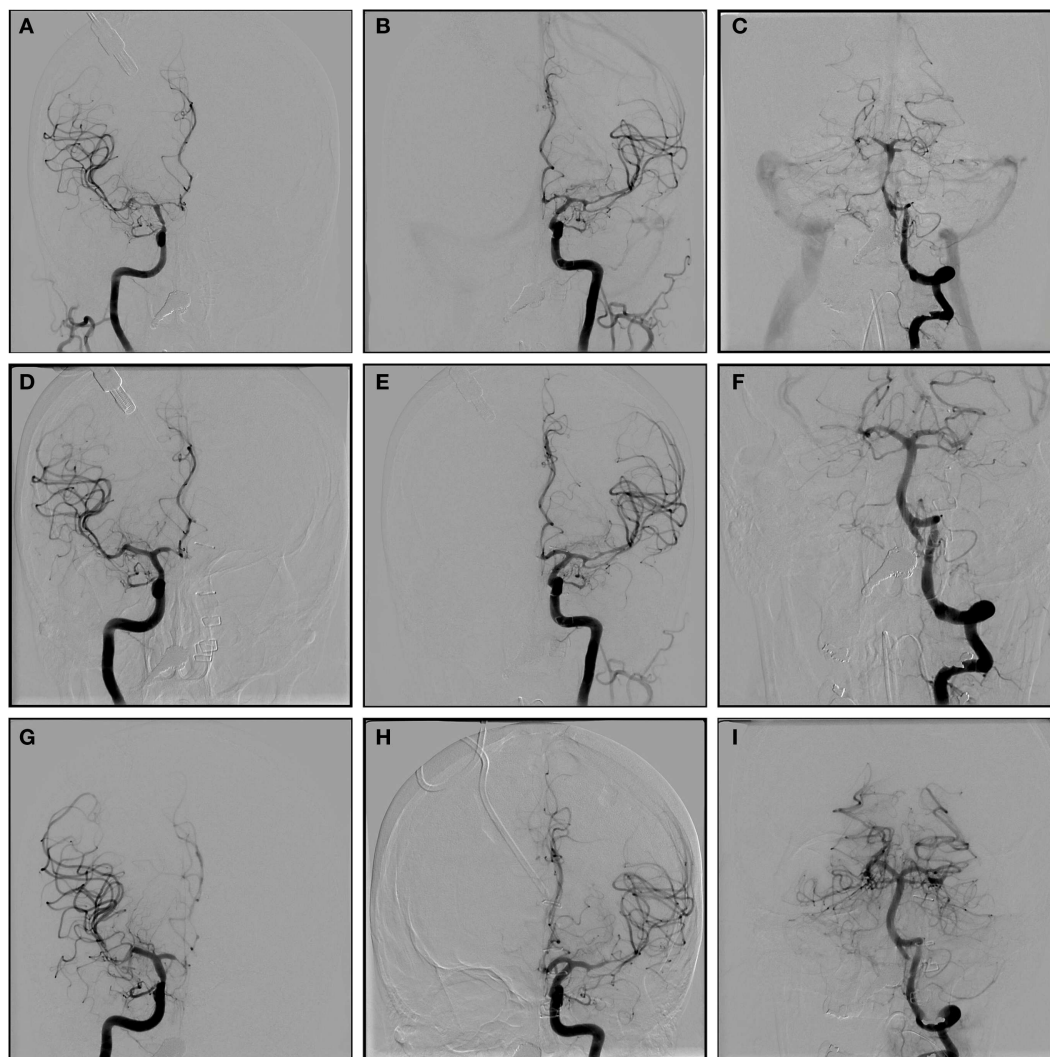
A-P angiographic images of a 58-year old woman with Hunt and Hess grade V subarachnoid hemorrhage from ruptured dissecting right vertebral aneurysm. Concern for vasospasm was generated from routine transcranial Doppler testing. The patient was already maximally medically managed so was taken for angiography. A-P images of RICA (A), LICA (B), and basilar artery (C) showing very severe vasospasm. A-P images of RICA (D), LICA (E), and basilar artery (F) immediately after
